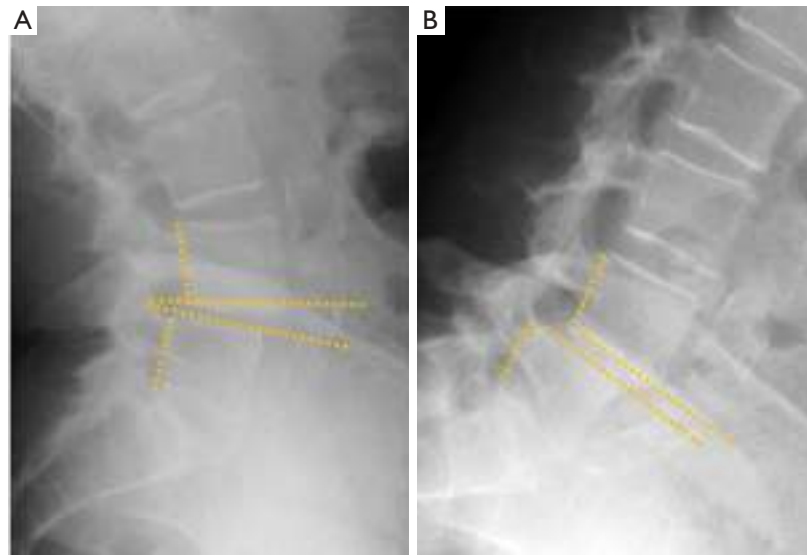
L4–L5 instability. Extension (A) and flexion (B) radiographs demonstrating 5 mm L4 forward displacement, with subsequent change of the L4–L5 disc angle approximately 20 degrees.
